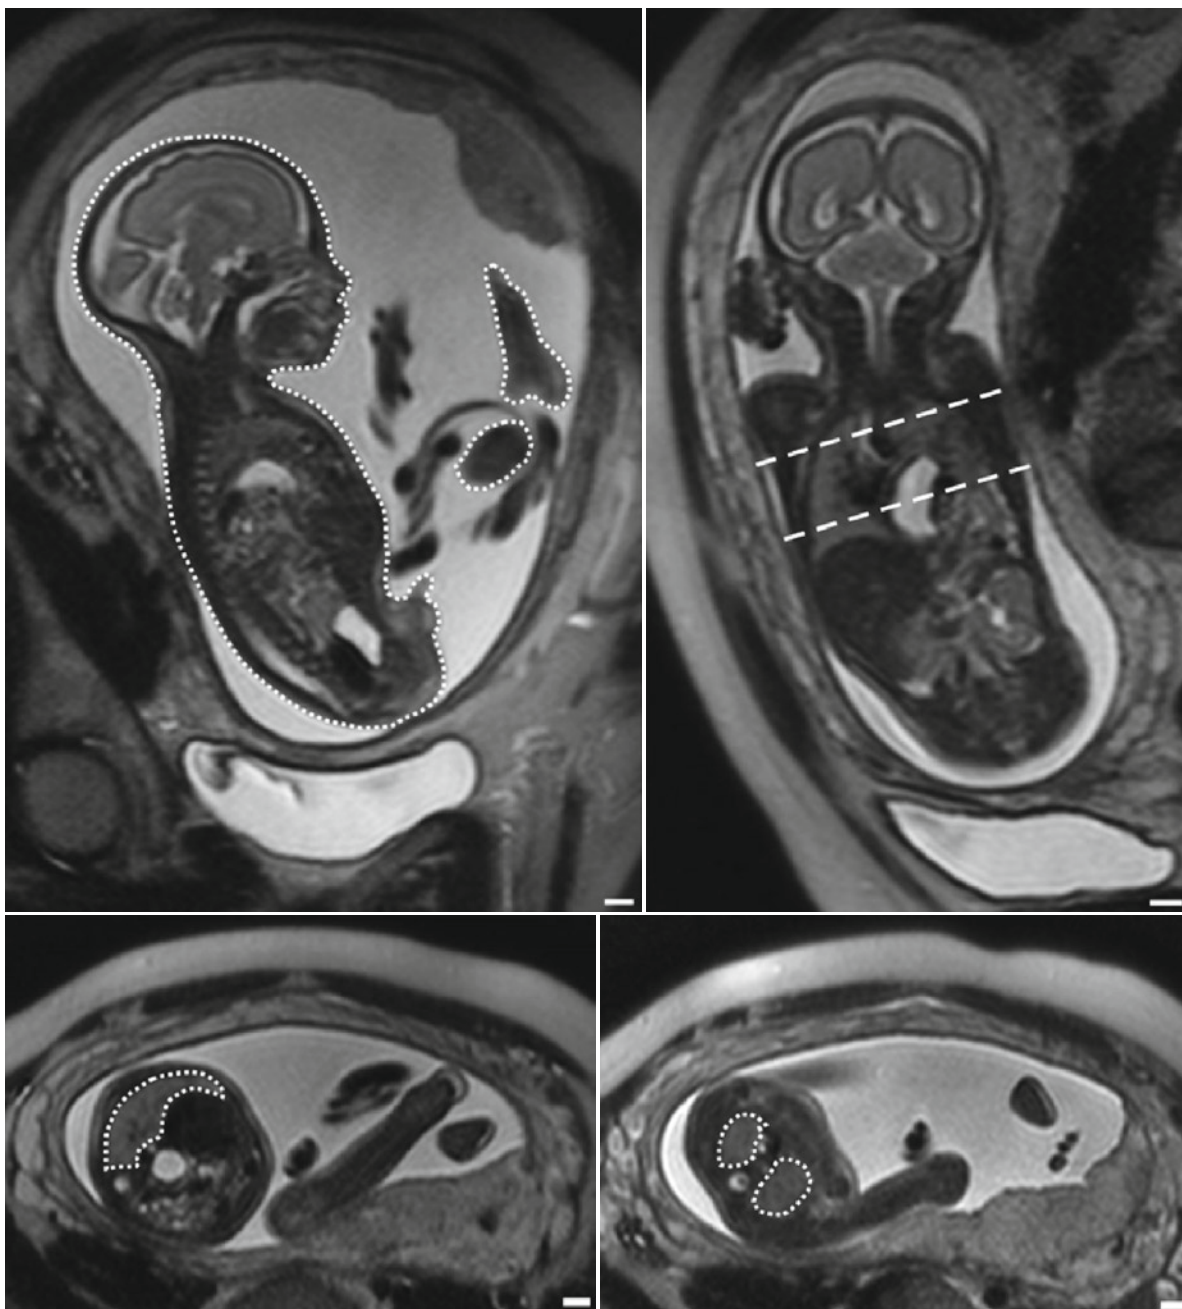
T2-weighted images of fetus with left sided CDH at 26 weeks without liver herniation. *Top left*, sagittal section with tracing of the body contours. *Top right*: coronal view of the fetus
